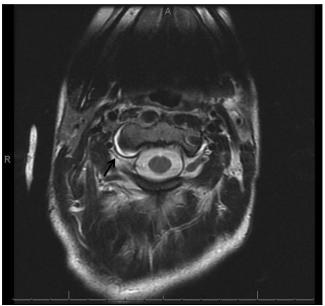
Axial view of MRI of cervical spine showing T2 hyperintense signal at the C1-C2 junction (black arrow) signifying joint effusion.
